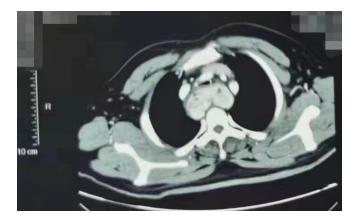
CT of the neck: posterior superior mediastinal esophageal travel area rich in blood supply occupying lesions, consider extraesophageal and intertracheal tumor lesions. This image shows the most obvious level of tracheal compression.
